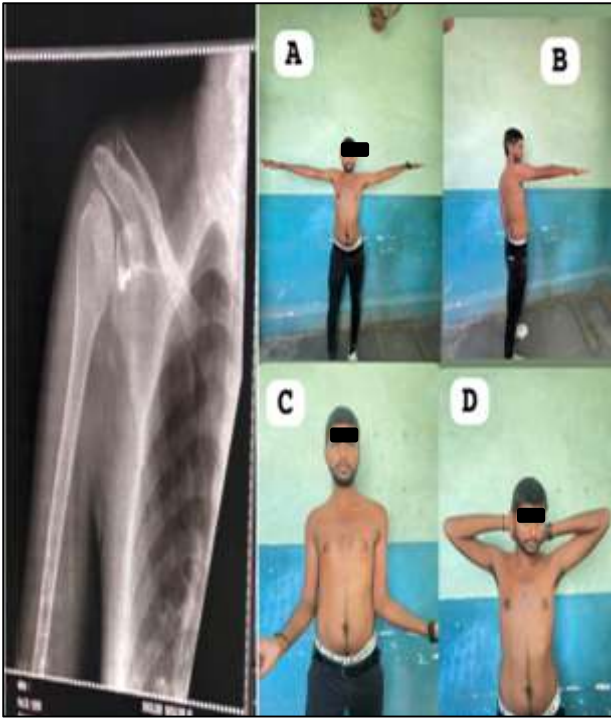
(A-D): 6 months followup x-ray and 6 months clinical rom.
